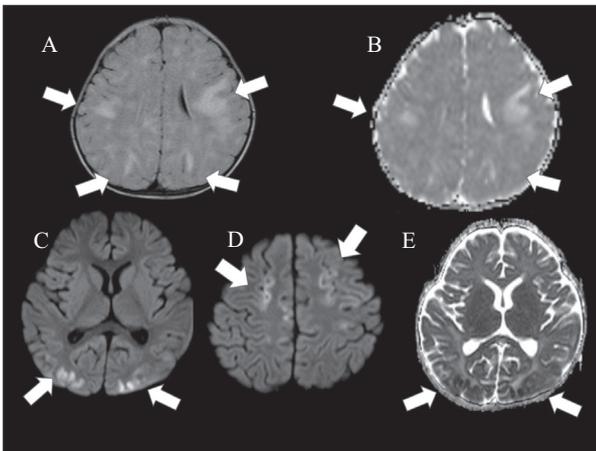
Serial MRI taken at a previous hospital at the onset of the neurological symptoms and on the 9th hospital day in case 2. (A) FLAIR and (B) Apparent diffusion coefficient (ADC) at the same level taken at a previous hospital at the onset of the neurological symptoms. (C, D) DWI and (E) ADC map at the same level as (C) on the 9th hospital day. FLAIR and ADC map taken at a previous hospital showed hyperintense white matter lesions in the bilateral frontal, temporal, and occipital regions (A, B, arrow). DWI on the 9th hospital day showed hyperintensity in the cortical regions in the bilateral occipital (C, arrow) and frontal lobes (D, arrow), as well as hyperintensity in the subcortical regions in the bilateral occipital lobes (C, arrow), which were considered as ‘T2-shine through’. ADC map on the same day showed hypointensity in the cortices, and hyperintensity in the adjacent subcortical white matter in the bilateral occipital lobes (E, arrow).
